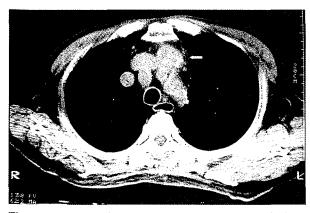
Chest CT scan shows a 3 cm tumor on the anterior mediastinum (h ollow arrow) with compression of the innominant vein.
